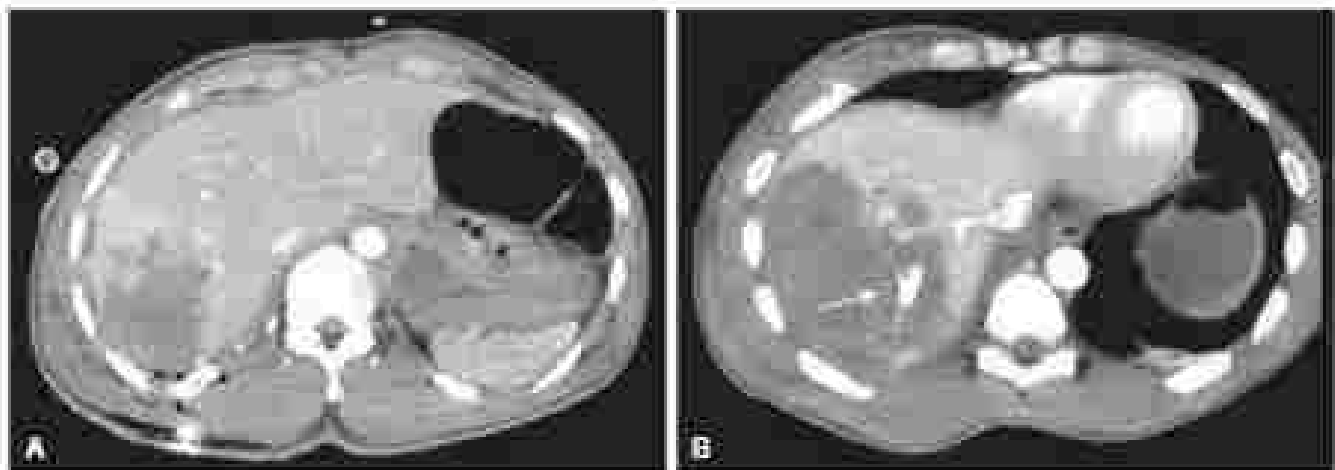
(A) Computed tomography (CT) image demonstrating liver injury with bullet posteriorly below skin (B) Gunshot wound to liver with acute arterial extravasation on CT scan (arrow)
